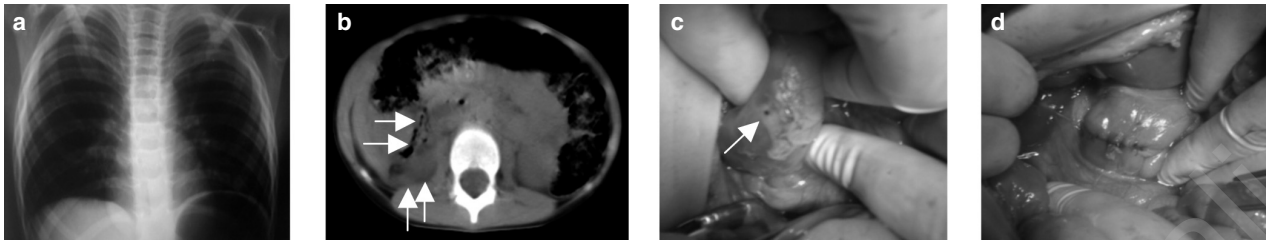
(a, b, c, d) - a) Plain abdominal X-ray was negative for free air. b) CT scan shows free air and fluid in retroperitoneal space. c). Intraoperative finding: perforation of the duodenum. d) Single layer suture repair of duodenum.
